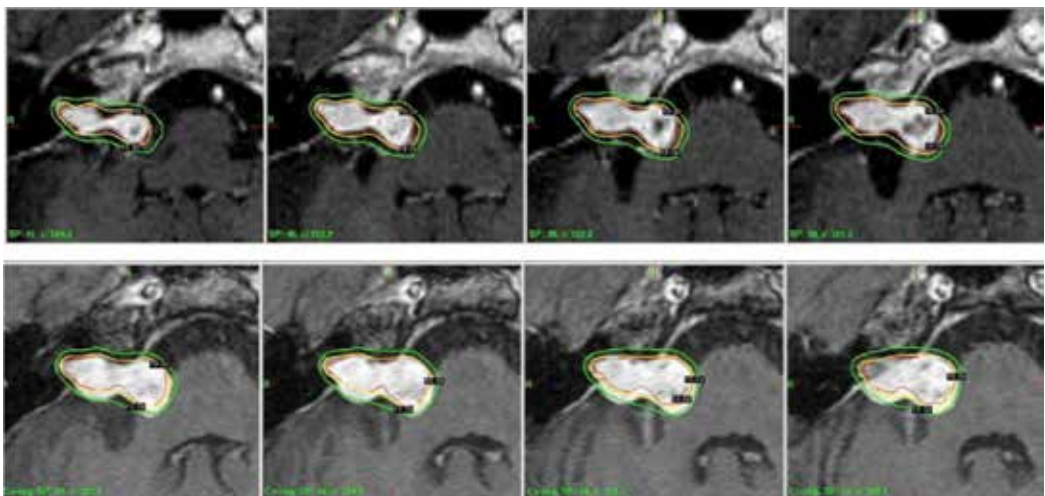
Axial MRI (T1-with contrast) of a VS case treated with Gamma Knife radiosurgery (13 Gy marginal dose) with follow-up MRI after 21 months (lower row) showed increase in tumor volume in comparison with the tumor volume before treatment (upper row).
